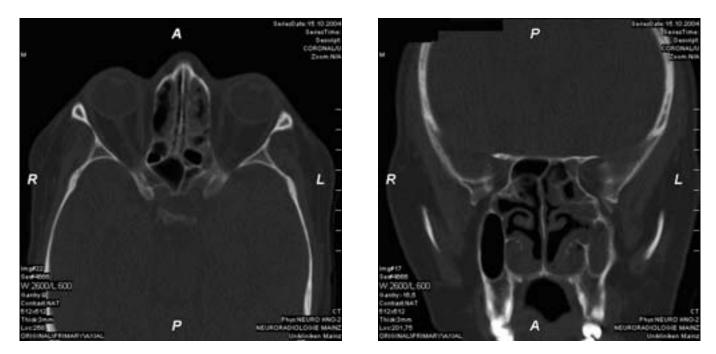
Preoperative *axial* (a, LEFT) and *coronal* (b, RIGHT) orbital CT-scan showing partial opacification of the left posterior ethmoidal cells in the area of the orbital apex close to the optic nerve canal.
